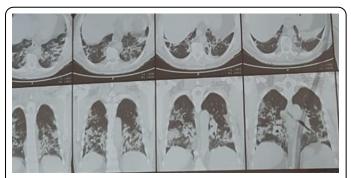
Showing CT scan of our patient with bilateral lung infiltrations.
